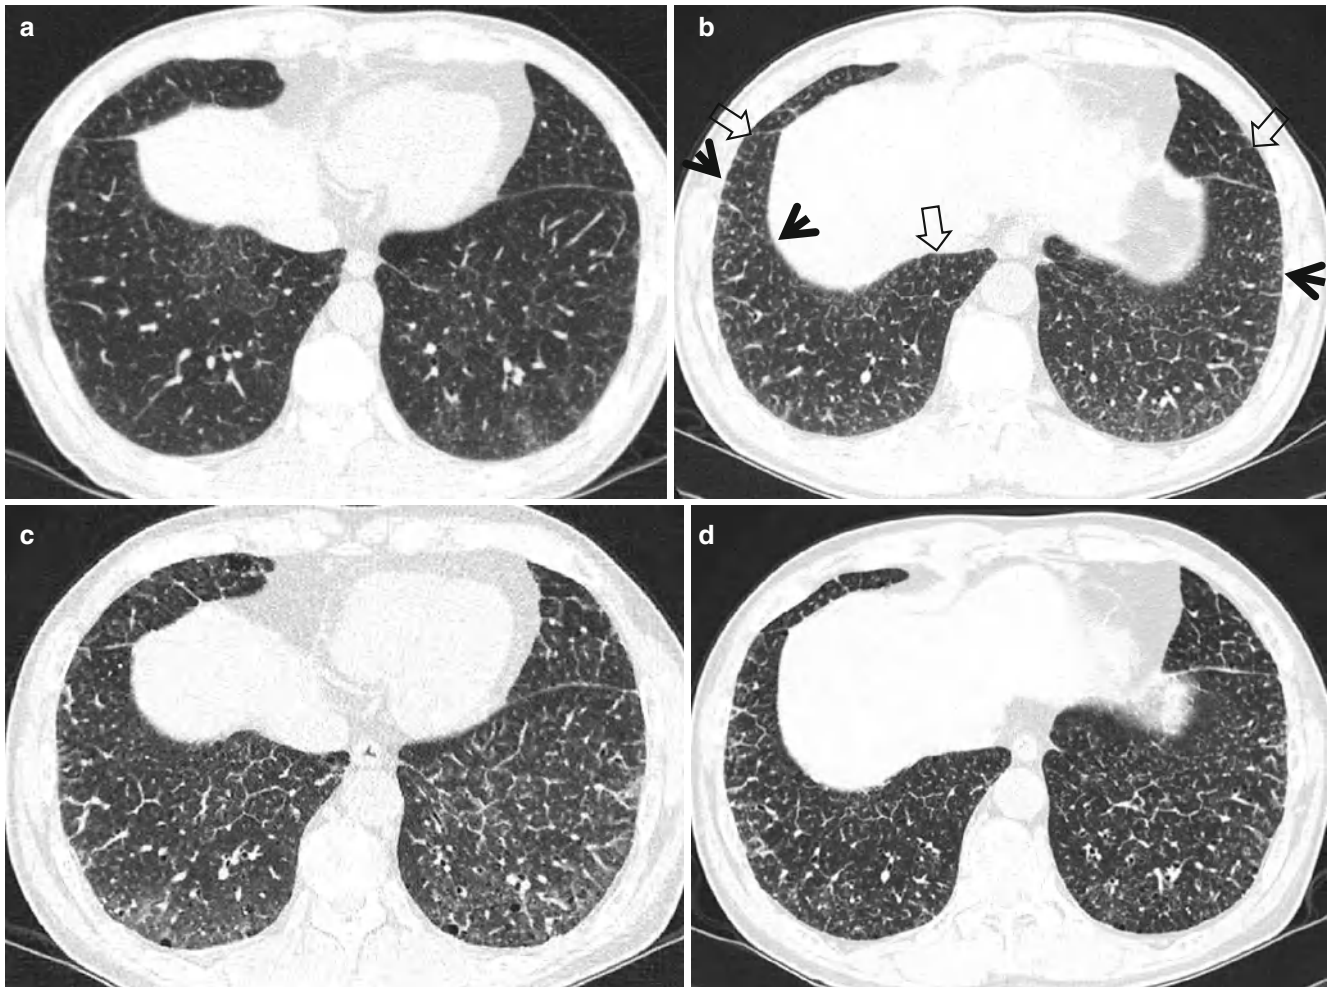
Alveoloseptal amyloidosis in a 58-year-old man who also has biopsy-proved gastric amyloidosis. (a, b) Lung window images of consecutive CT (2.5-mm section thickness) scans obtained at level of liver dome show small nodules along pleura (*arrows*) and smooth or mildly nodular thickening of interlobular septa (*open arrows*). Also
